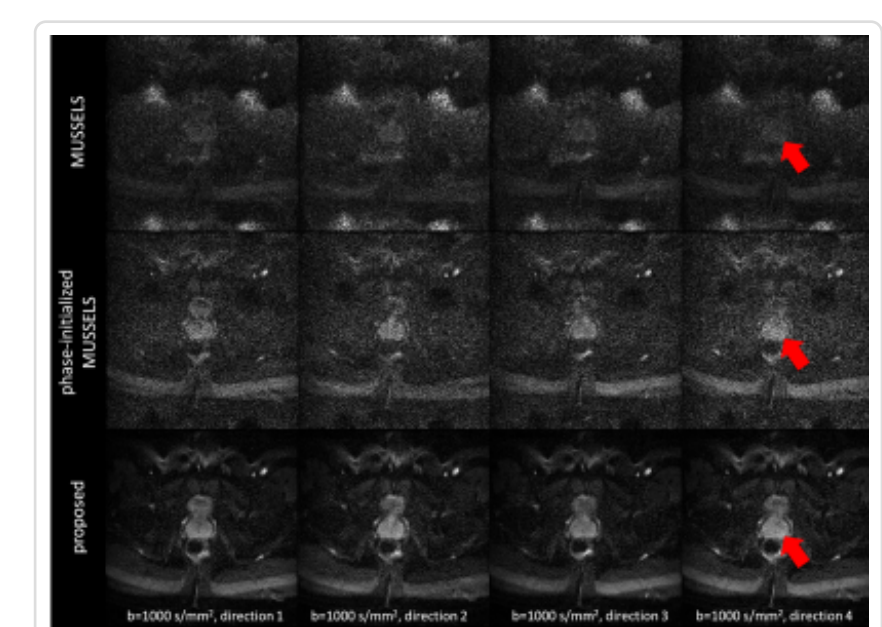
Multi-scale low-rank reconstruction of a high-resolution (1 mm^2) prostate DWI dataset with 8 frames, showing only 4 different diffusion directions $b=1000 \text{ s/mm}^2$ images, comparing with original and phase-initialized MUSSELS reconstruction. With joint phase initialization, the image quality can be slightly improved from the original MUSSELS but there is still too much noise present. The proposed method can significantly improve the image quality and remove the noise (red arrows).
